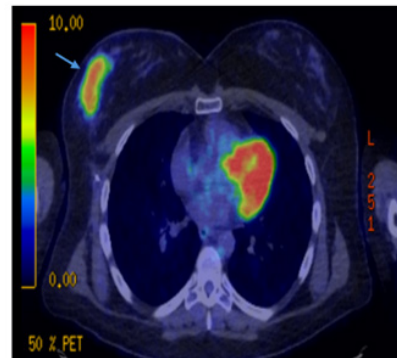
FDG-PET demonstrating heterogenous mass-like uptake in the lateral right breast (arrow).
